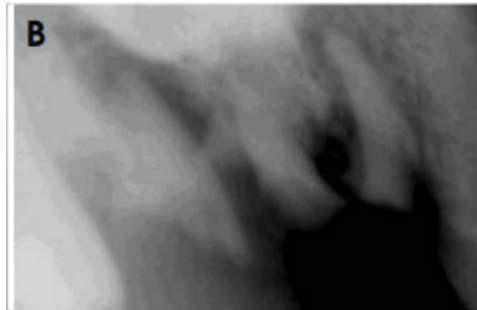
The image of extraoral radiography (Kumar et al., 2011).
